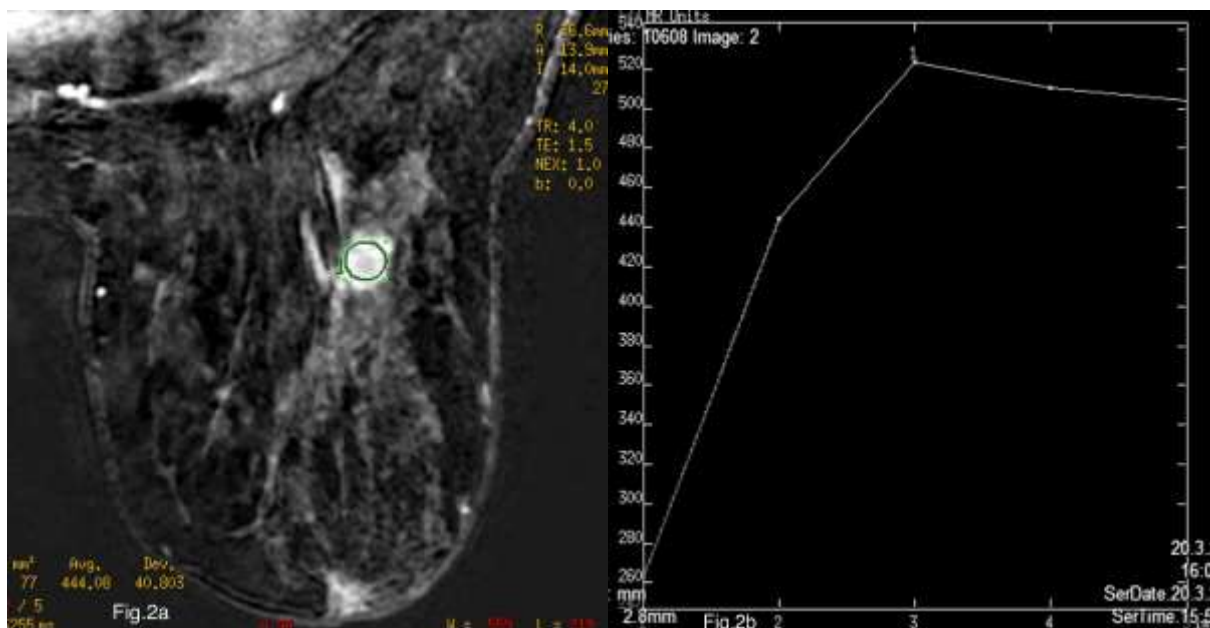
Dynamic contrast enhanced breast MRI shows a mass with irregular margins in 53-year-old woman. Final pathology showed grade-3 invasive ductal carcinoma. Percentage of Ki-67 were 50%, estrogen and progesterone receptors were 50% and 70% respectively, and c-erb-b2 receptor score was 3 in the tumor.
